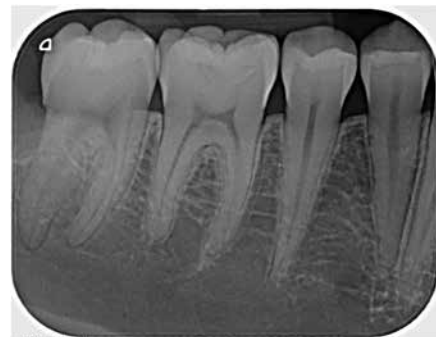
Follow up radiograph dated December 2016, of class 1 GCP Glass Fill restoration 46 placed over deep caries in February 2015.
